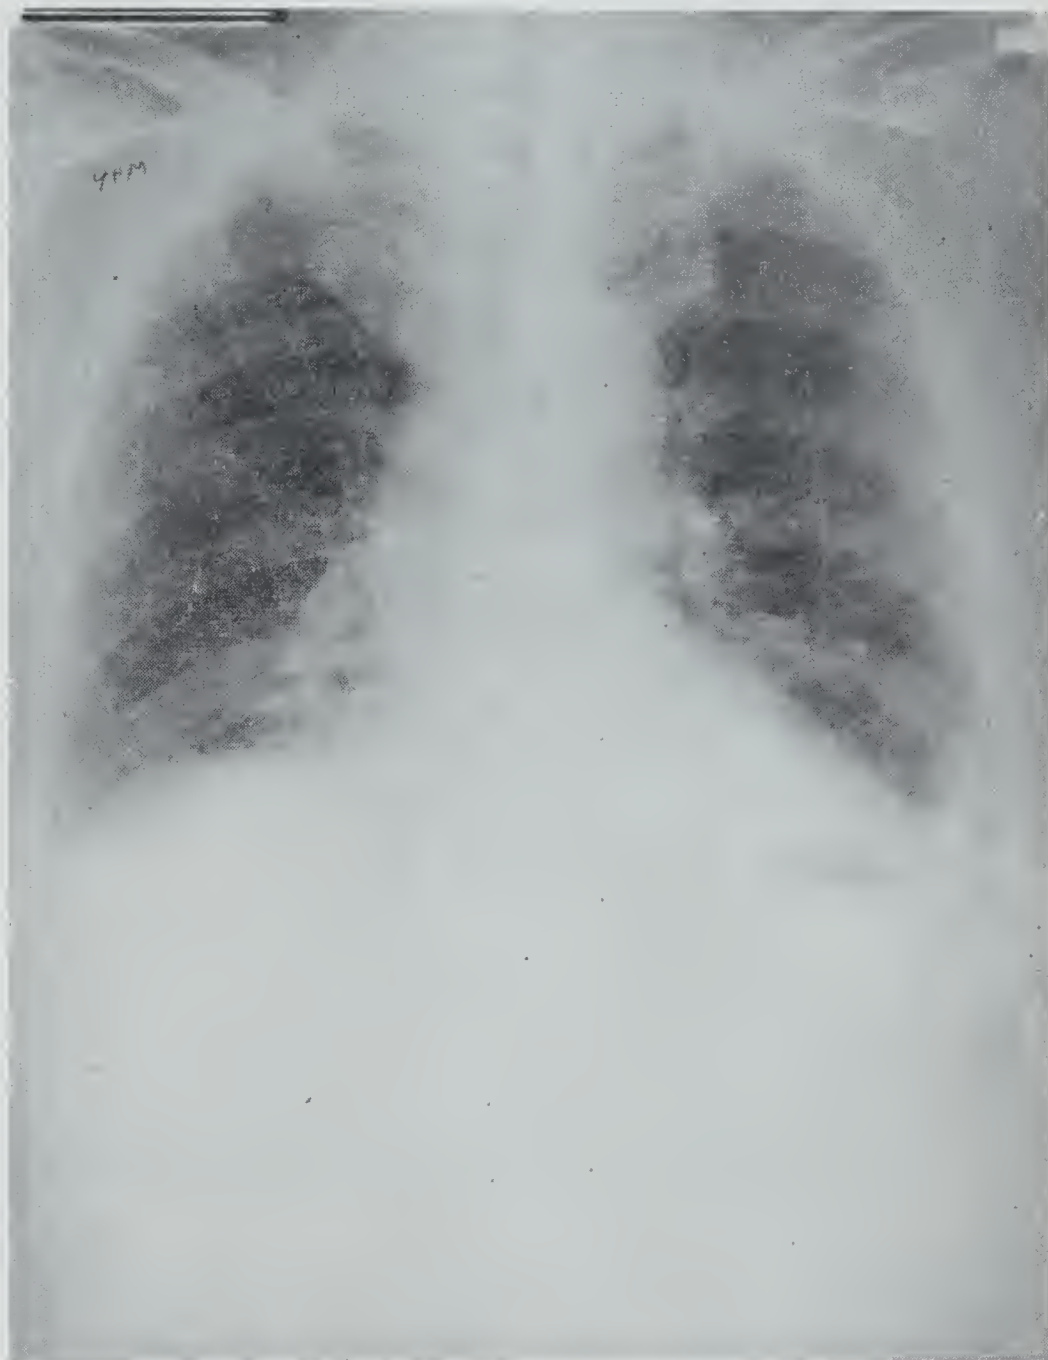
Portable x-ray of chest taken at 4 a. m. No definite fluid can be seen even on careful reevaluation. There is no mediastinal emphysema.
